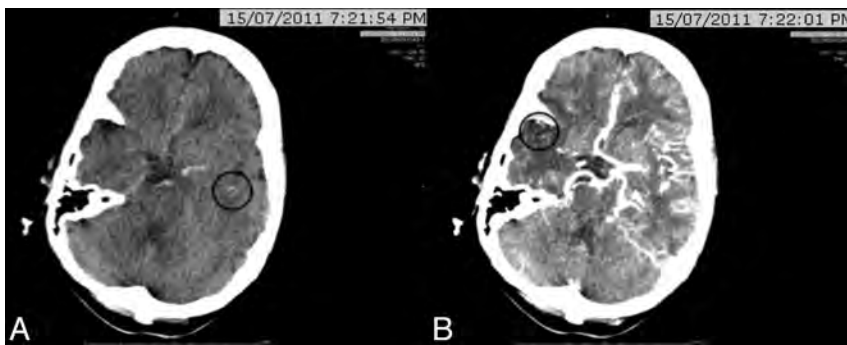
A 67-year-old woman with left hemiparesis and dysarthria who presented to the hospital 2 hours after onset. CTA identified a right intracranial ICA occlusion. CTP-SI showed that the contrast (black circles) was first detected at 20 seconds in the left Sylvian fissure (A) and at 27 seconds in the affected right hemisphere (B). The relative filling time delay was, therefore, 7 seconds.
